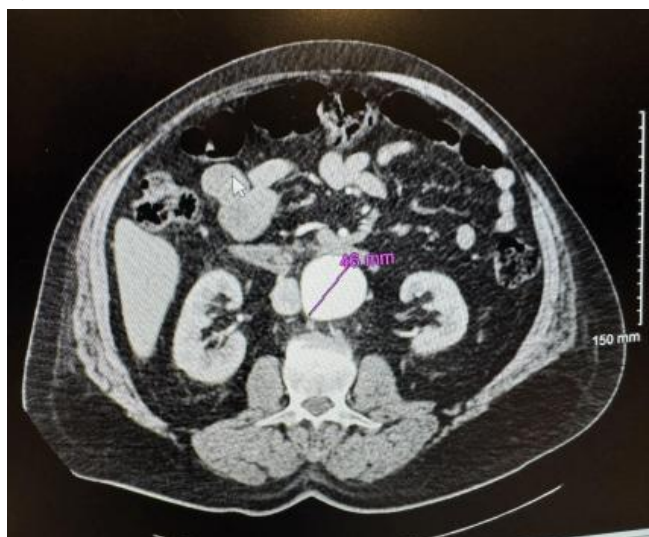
Computed tomography of the abdomen demonstrating an infrarenal abdominal aortic aneurysm measuring approximately 4.2×4.0 cm, supporting the presence of systemic aneurysmal disease
